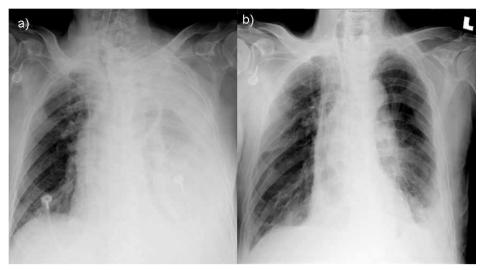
Chest X-rays showing before a) and after b) airway Ultraflex stent implantation in esophageal cancer with respiratory failure. Successful extubation was performed after SEMS implantation.
